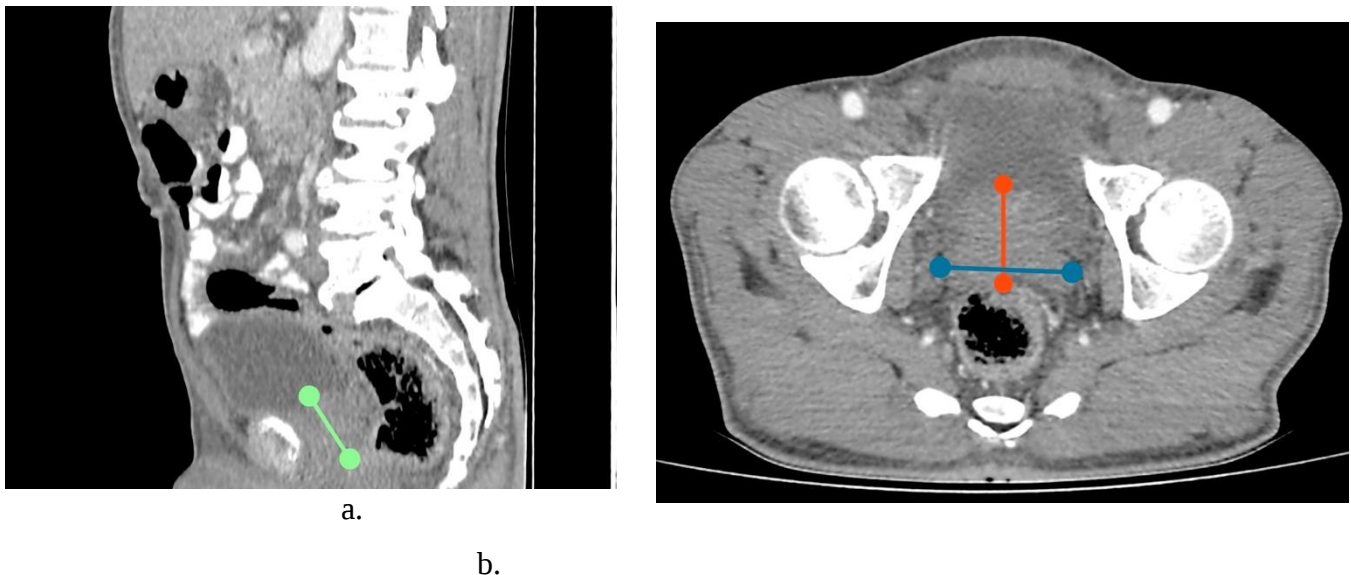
Sagittal CT scan image of the pelvis showing how to measure the height of the prostate gland (green line).
